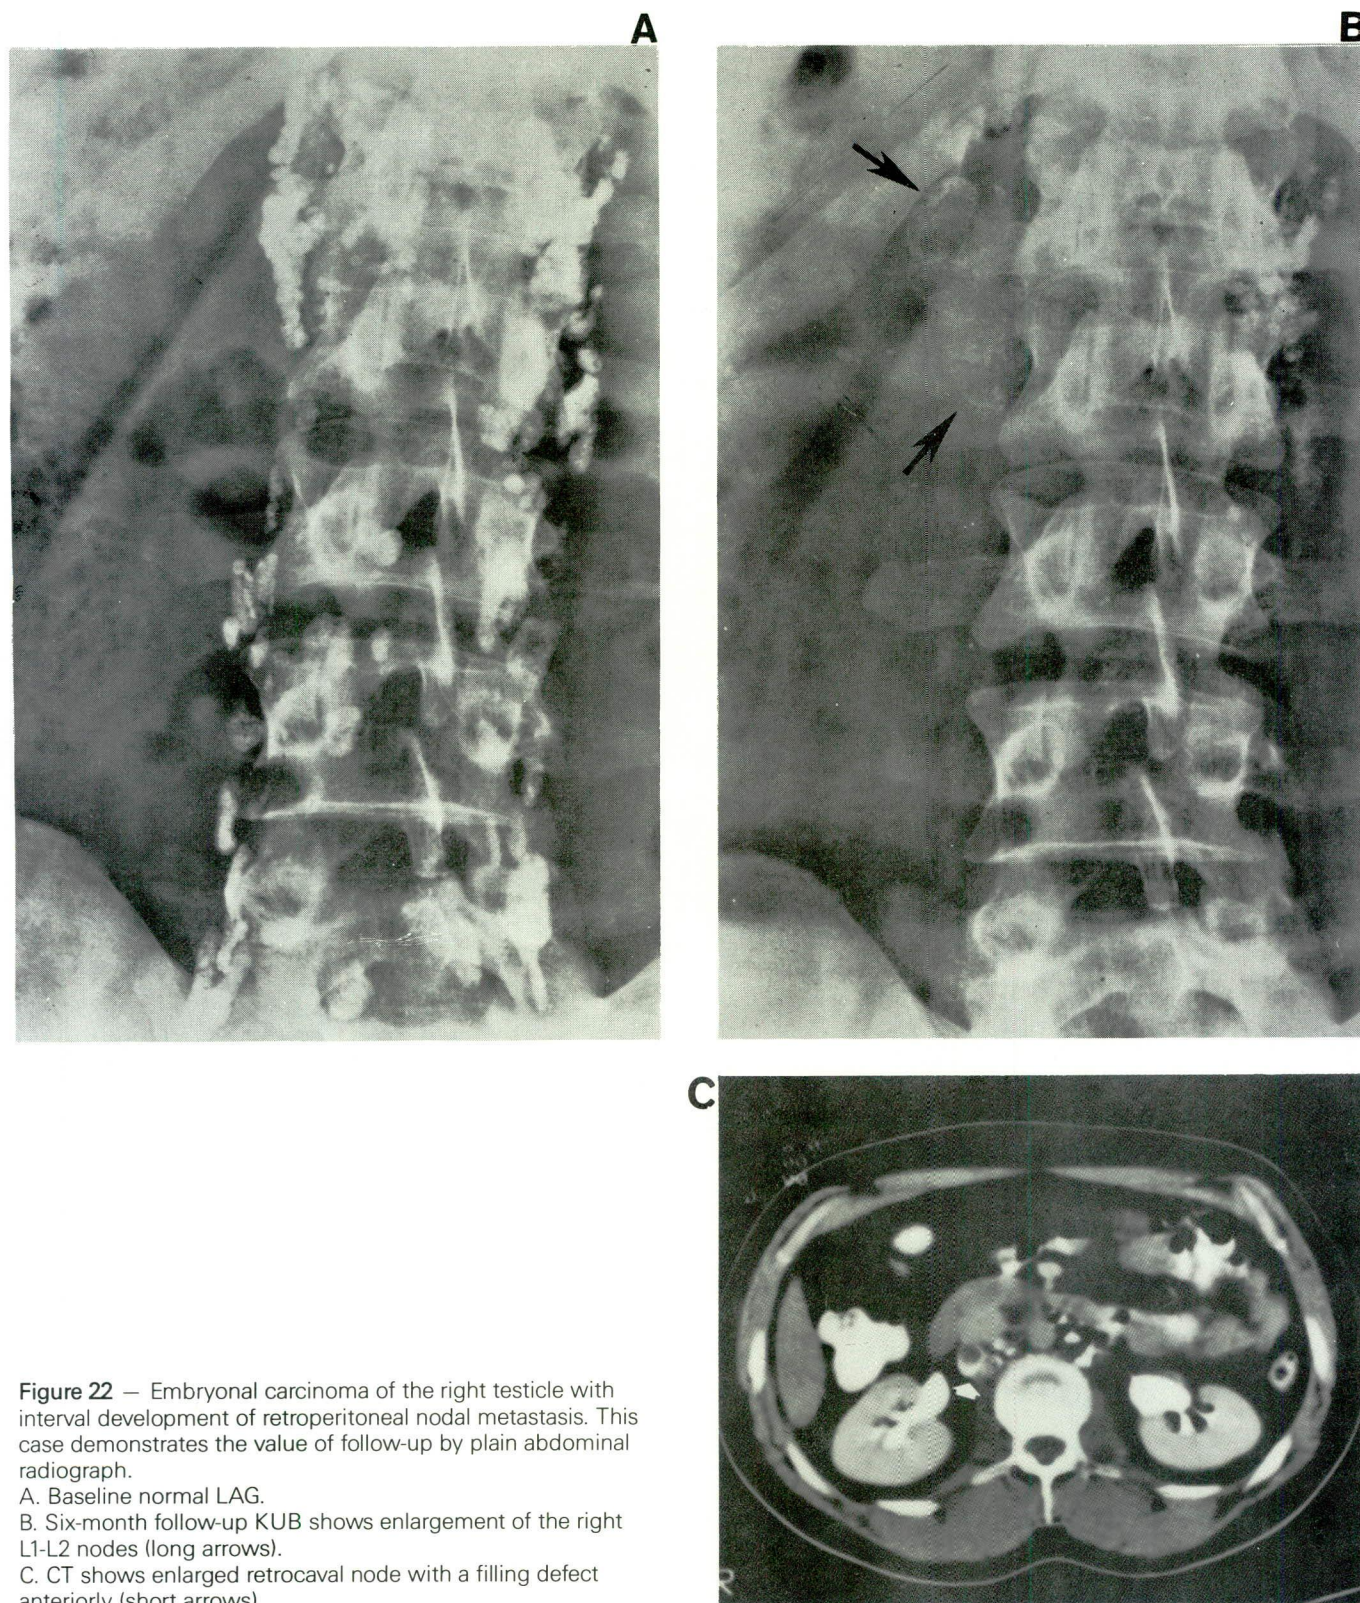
Embryonal carcinoma of the right testicle with interval development of retroperitoneal nodal metastasis. This case demonstrates the value of follow-up by plain abdominal radiograph.
